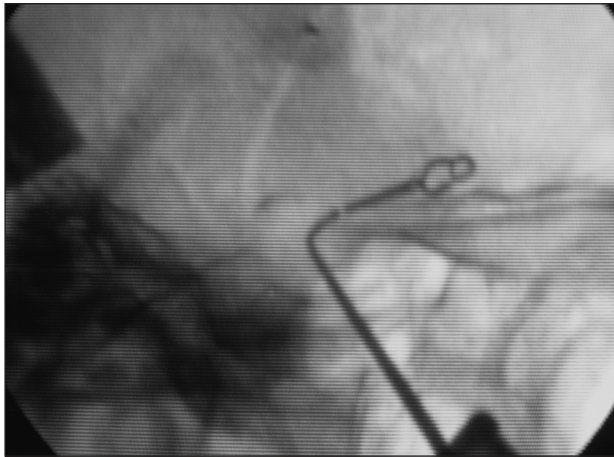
An intraoperative plain film showing a lateral view of the sellar region depicting the relationship between the previously clipped ICA and the curette during the transsphenoidal removal of adenoma.
